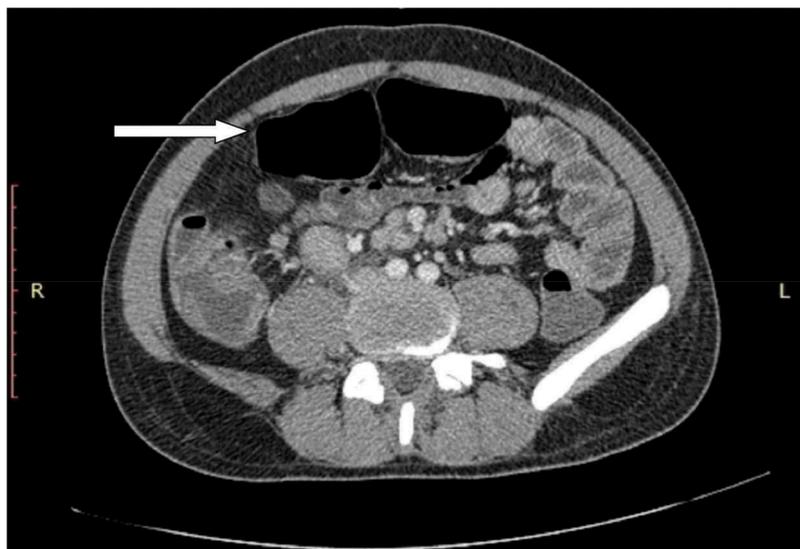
Computed Tomography (axial view) reveals a gas-filled loop without haustration marks.
